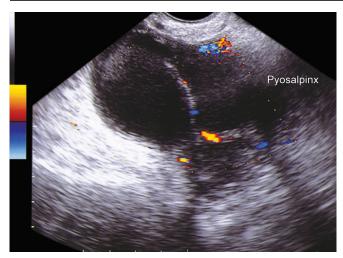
Pyosalpinx. Incomplete septa. When the fallopian tube is dilated and folded, a sonographic sign of incomplete septa is seen. Echorefringent material inside the fallopian tube
